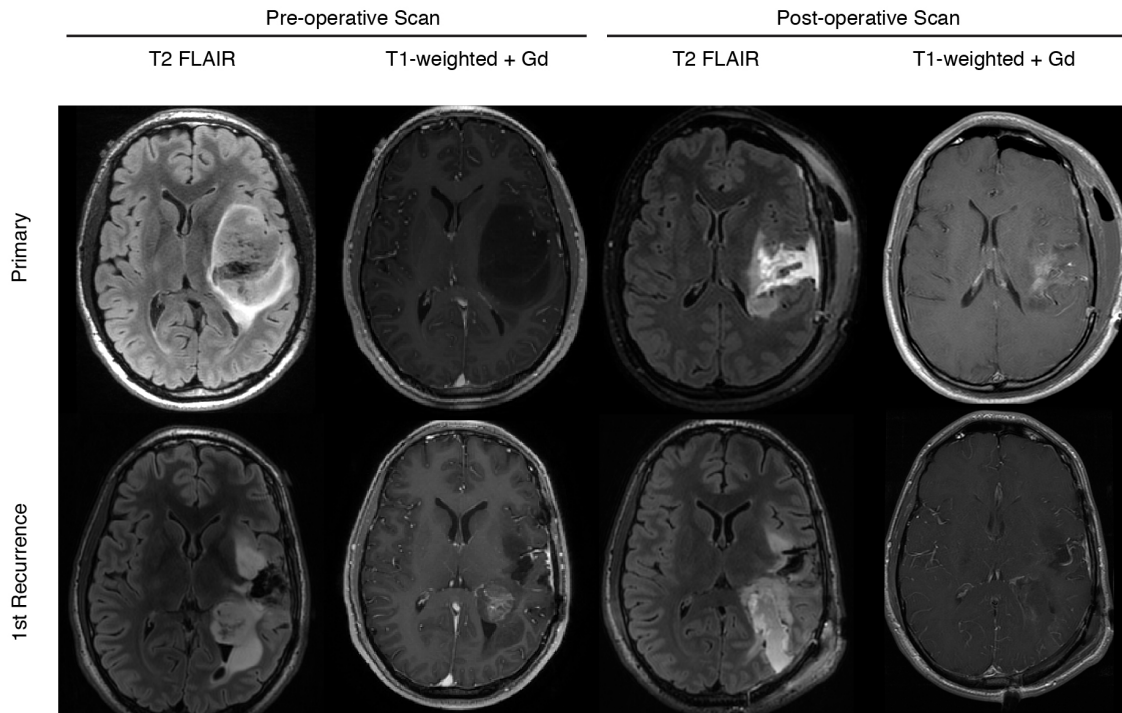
Pre- and post-surgical MR imaging of patient 17. T1- and T2-weighted images representative of the tumor region before and after the initial resection and recurrence. Imaging for the initial resection demonstrated a large T2 hyperintense non-enhancing mass situated in the left insula with significant mass effect on the left lateral ventricle. After a near gross total resection the pathological diagnosis was a WHO grade II oligodendroglioma. Significant T2-hyperintensity and tissue shifts were observed post resection. At the time of recurrence, an enhancing mass centered in the left posterior temporal and parietal white matter was noted with interval growth, avid heterogeneous enhancement, and MR features consistent with upgrade to a high-grade neoplasm. Abnormal susceptibility and T1-hyperintensity with focal reduced diffusion (not shown) in the center of the mass was consistent with central necrosis. Surrounding masslike T2
